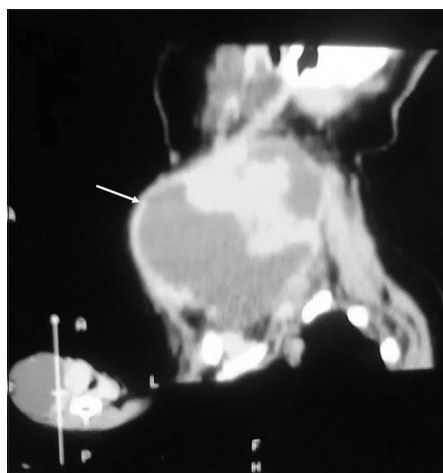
Computed tomography scan showed lateral cervical mass measured 10 cm × 13 cm and had a predominantly cystic composition
